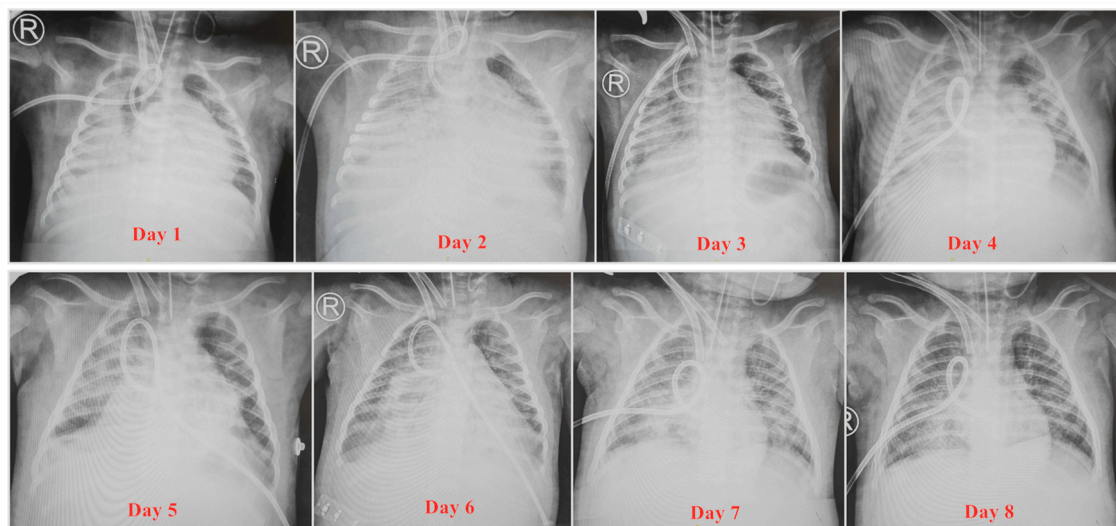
Changes in chest X-rays during ECMO treatment.
